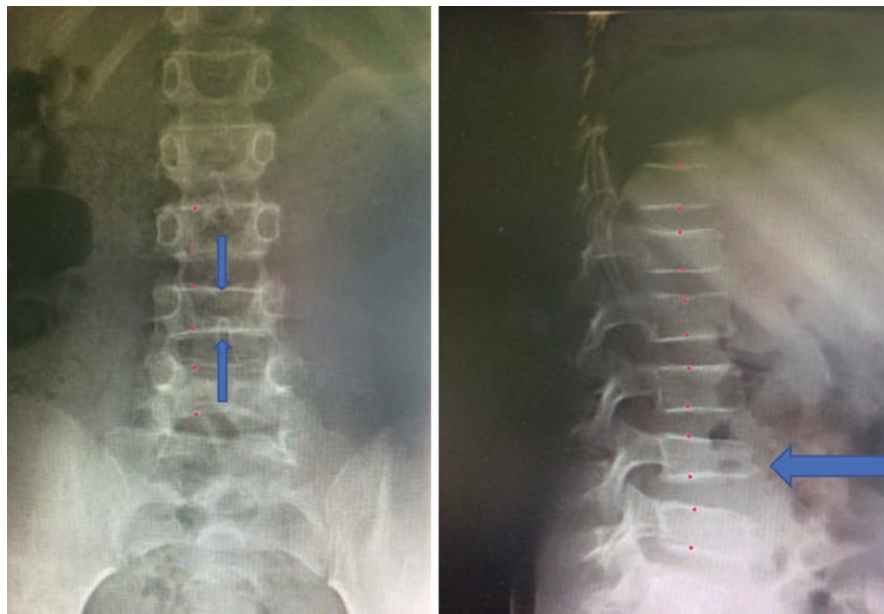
AP and lateral radiographs of a 5-year-old girl with several weeks of back pain showing prominent vertebral end plates also known as “banding” (red dots), diffuse osteopenia, and compression fracture of L4 (vertical arrows). Her WBC count and differential were *normal*, but bone marrow aspirate showed leukemia
